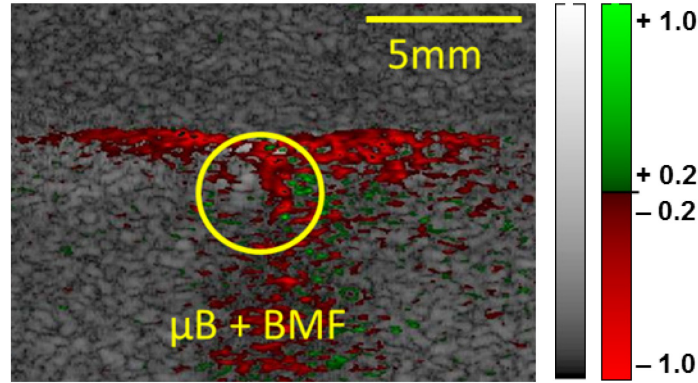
Flash-difference images with a single angle image sequence of microbubbles. A tube (shown as yellow circles) was placed 2 cm deep in tissue mimicking gelatin. Blood mimicking fluid (BMF) with 5% microbubbles (μB) flowed through the tube at 1 mL/min. A 1000 cycles, 1.7 MI ultrasound activation pulse was used to destroy the microbubbles. The gray and red-green colormap represents ultrasound signal before the HIFU pulse and the percent change in ultrasound signal after the HIFU burst, respectively [35].
